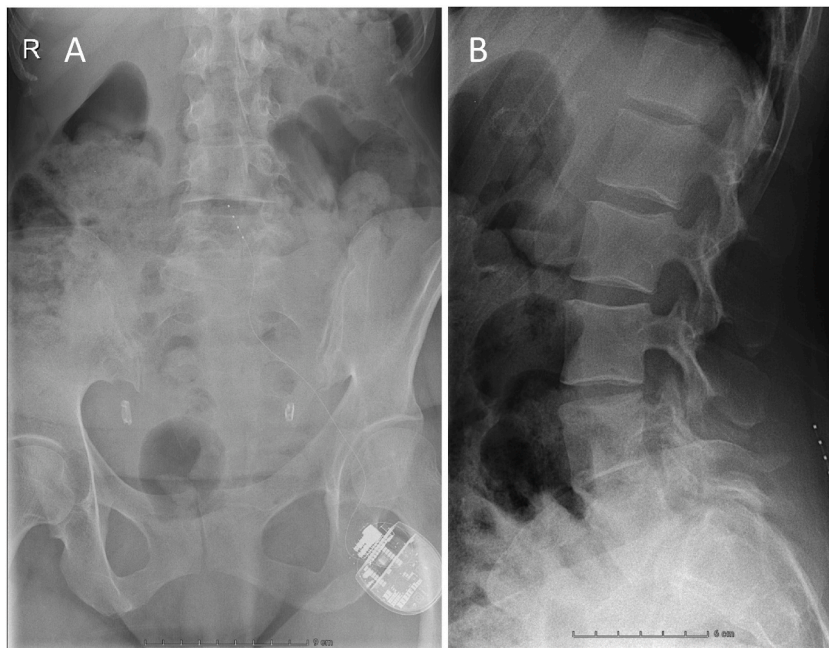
Lumbar X-ray 2 months after open revision of the DRG-S showing electrode migration. (A) Anteroposterior view, (B) sagittal view. DRG-S, dorsal root ganglion stimulator.
